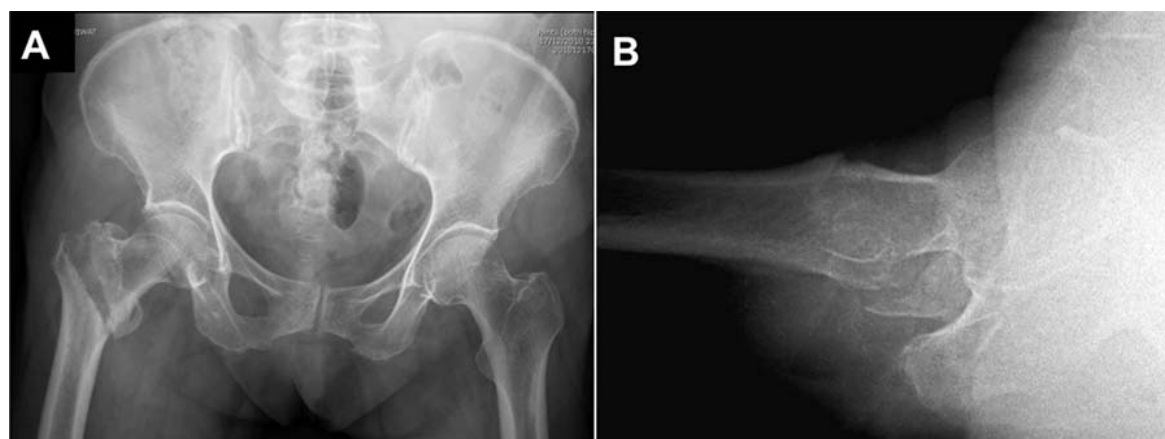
Case examples of a 70-year-old female with right intertrochanter fracture (ITF) that having treatment change after using hip lateral radiograph. The both hips AP radiograph (A) showed displaced ITF with minimal fracture comminution, and therefore all observers selected treatment as dynamic hip screw fixation. However, the hip lateral radiograph (B) showed additional information as fracture greater trochanter in which resulting in changing of treatment to proximal femoral nail in two observers.
